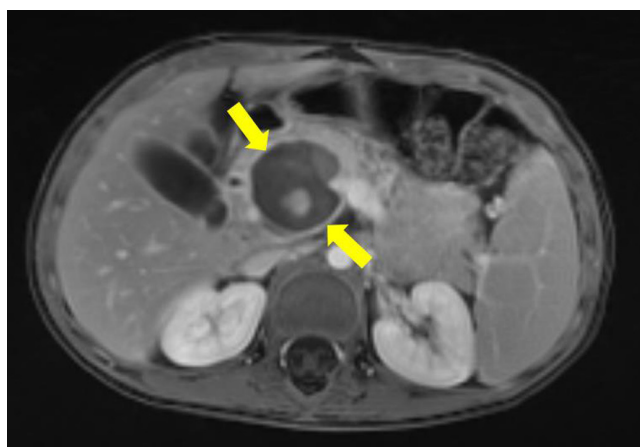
MRI abdomen T1 VIBE postcontrast axial image. No flow or enhancement is seen within a 3-cm lesion within the pancreatic head (arrows). This image is unchanged compared with the precontrast VIBE sequence. MRI = magnetic resonance imaging; VIBE = volumetric interpolated breath-hold examination.
